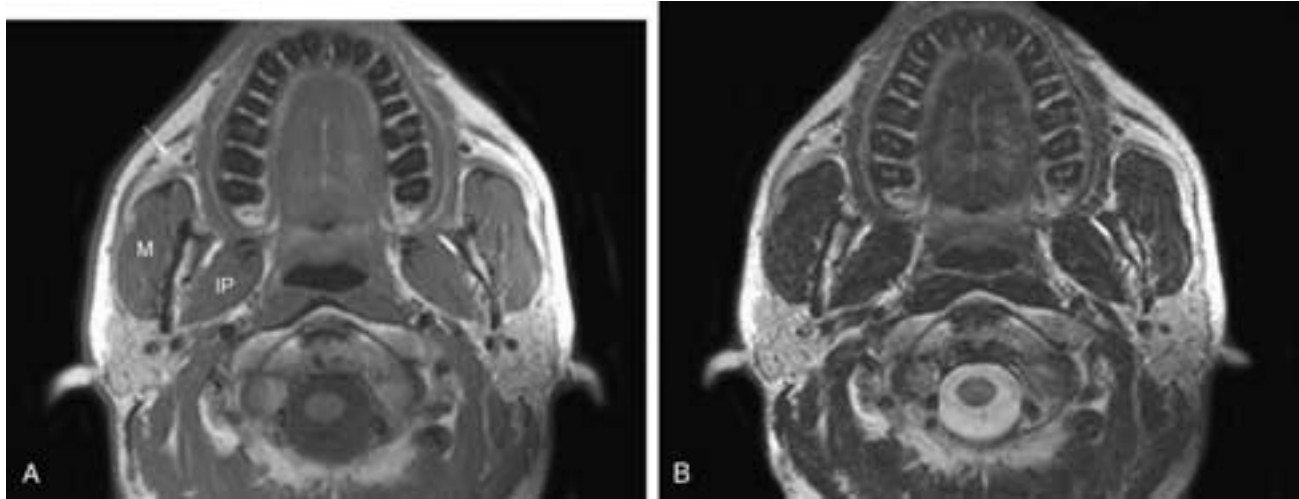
Axial T1-weighted (A), and T2-weighted (B), MR images through the parotid glands. Note the signal voids of the retromandibular vein and external carotid artery just dorsal to the ramus of the mandible. Also note the relationship of the masticator space (M, masseter muscle; IP, internal pterygoid muscle) and the buccal fat pad (arrow in A) to the parotid gland.
